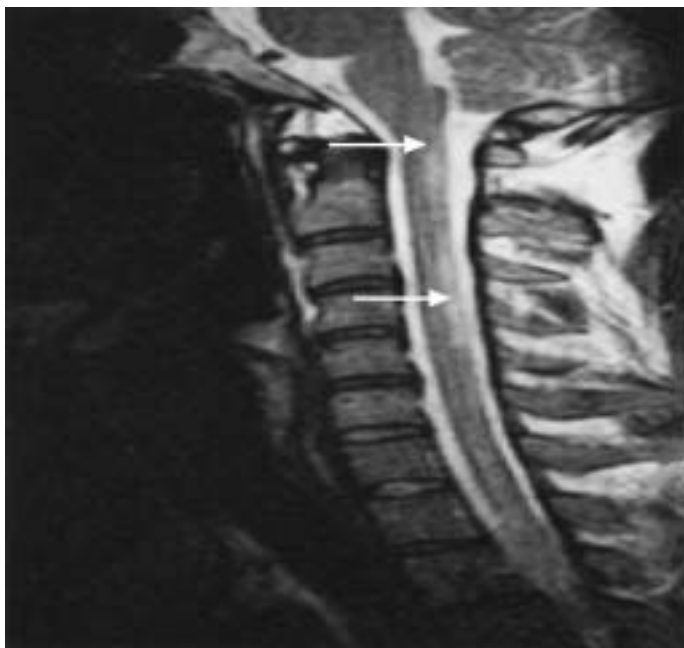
T2-weighted magnetic resonance imaging of the cervical spine in case C, showing hyperintense lesions at the 2nd–5th cervical spinal level (arrows)
